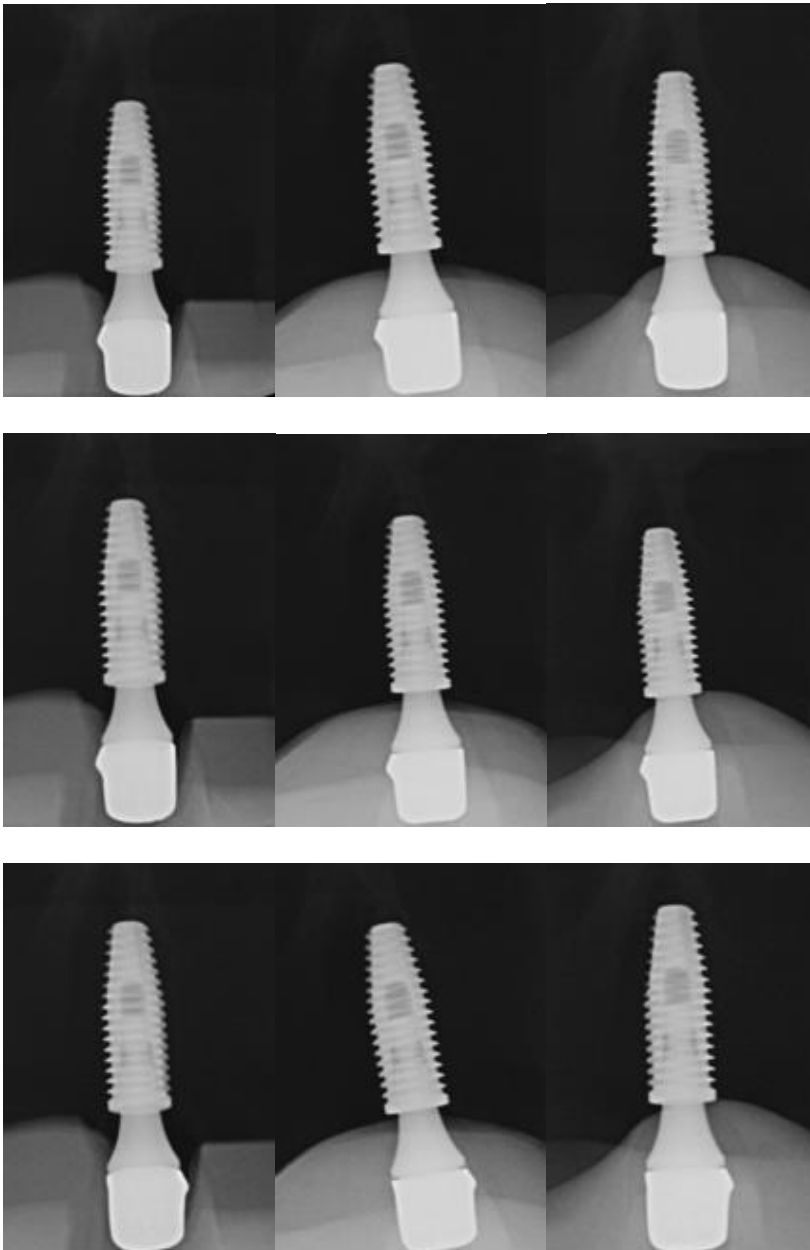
Radiografias obtidas para estudo. A, Grupo controle. Técnica periapical da bissetriz. B, Grupo controle. Técnica periapical do paralelismo. C, Grupo controle. Técnica periapical do paralelismo modificado. D, Grupo 50 μm . Técnica periapical da bissetriz. E, Grupo 50 μm . Técnica periapical do paralelismo. F, Grupo 50 μm . Técnica periapical do paralelismo modificado. G, Grupo 100 μm . Técnica periapical da bissetriz. H, Grupo 100 μm . Técnica periapical do paralelismo. I, Grupo 100 μm . Técnica periapical do paralelismo modificado. J, Grupo 150 μm . Técnica periapical da bissetriz. K, Grupo 150 μm . Técnica periapical do paralelismo. L, Grupo 150 μm . Técnica periapical do paralelismo modificado.
